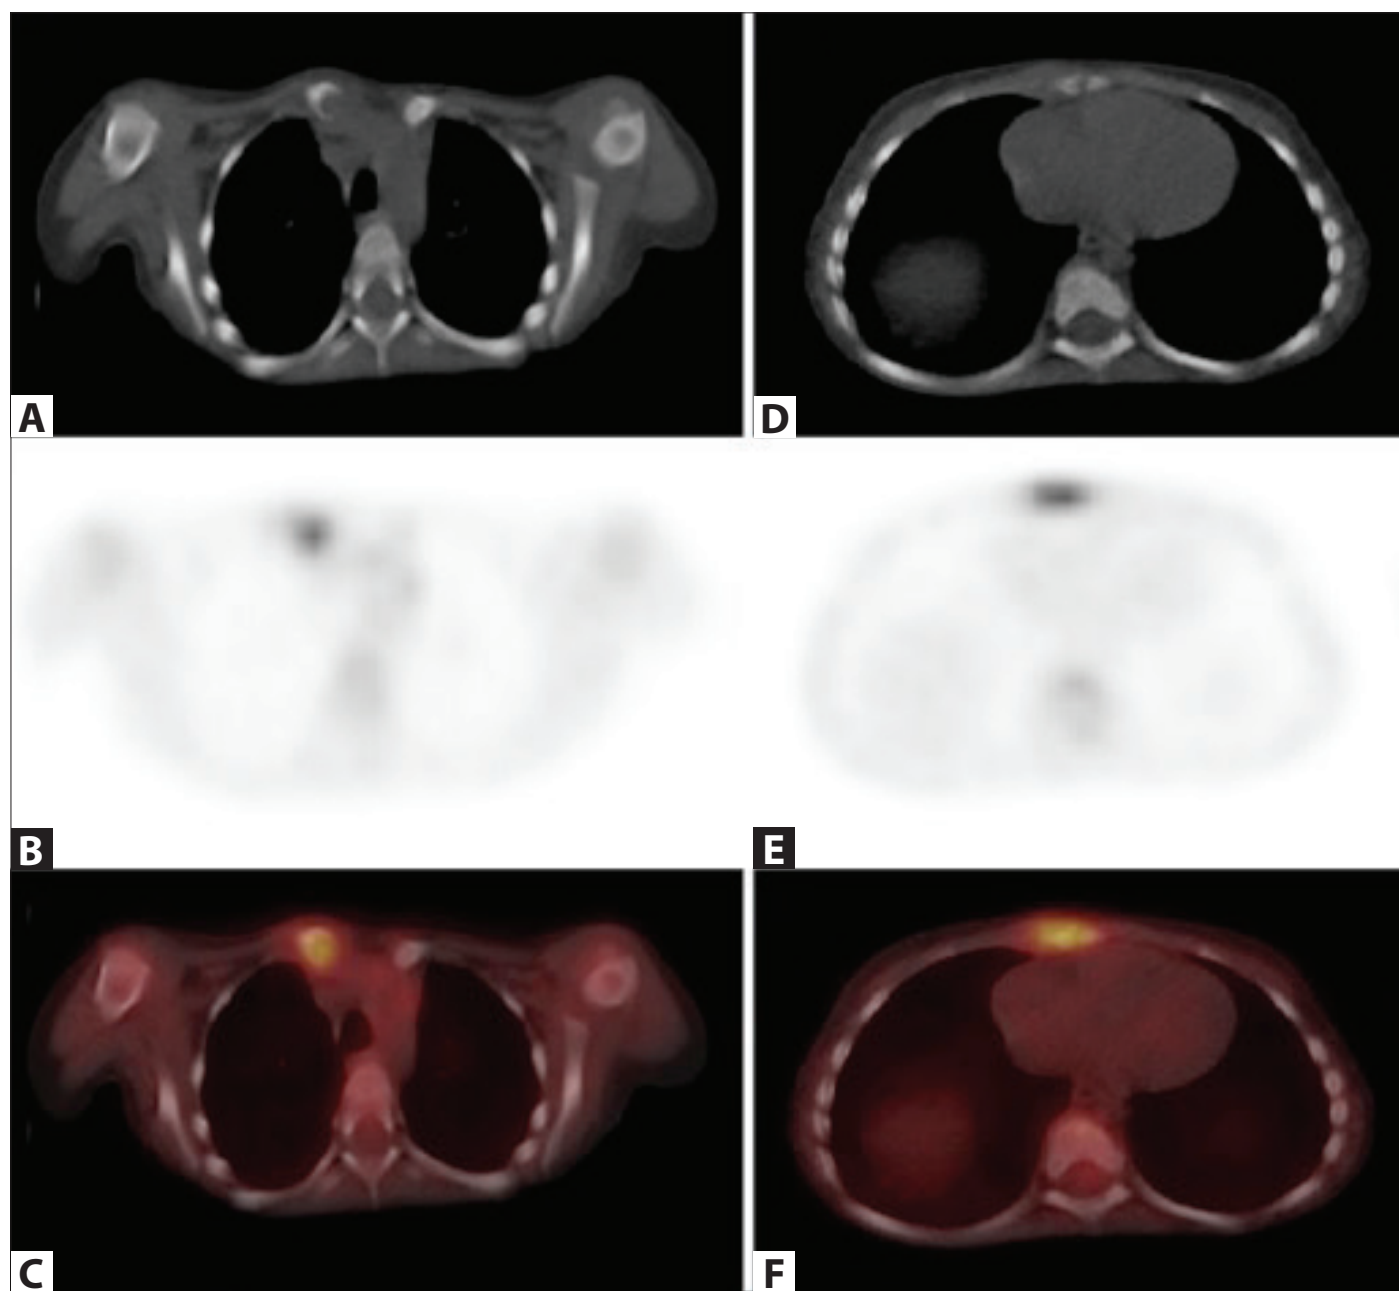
FDG uptake at the proximal end of the right clavicle (A. CT, B. PET and C. PET/CT) and in the middle part of the corpus sterni (D. CT, E. PET and F. PET/CT).
